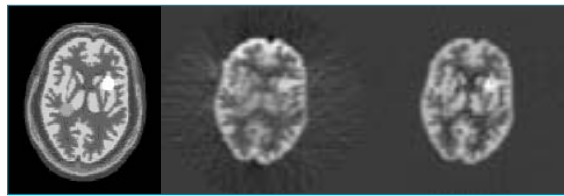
Comparison of our quantitative SPECT reconstruction (right) with the conventional reconstruction (middle) for the 3D Hoffman brain model (left). Our analytical approach achieved the quantitative reconstruction of $128 \times 128 \times 32$ array size in less than 5 minutes by a HP/J210 desktop computer without transmission scan due to the unique head attenuation property (although transmission scans are usually required for photon attenuation compensation in SPECT).
